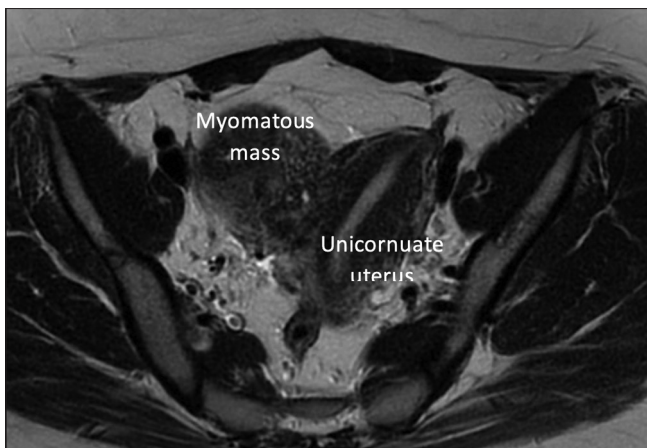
Pelvic magnetic resonance imaging with contrast describing a right adnexal mass, to consider a uterine leiomyoma with subserous component
